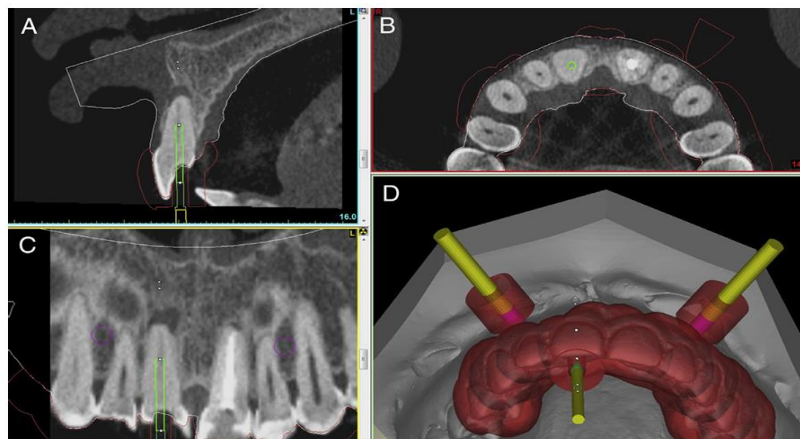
A CBCT image of the right maxillary central incisor with severe PCC and apical periodontitis. (A–C) Virtual planning of guided endodontics. (D) The model scan aligned to the 3D template and the virtual copy of the drill.
